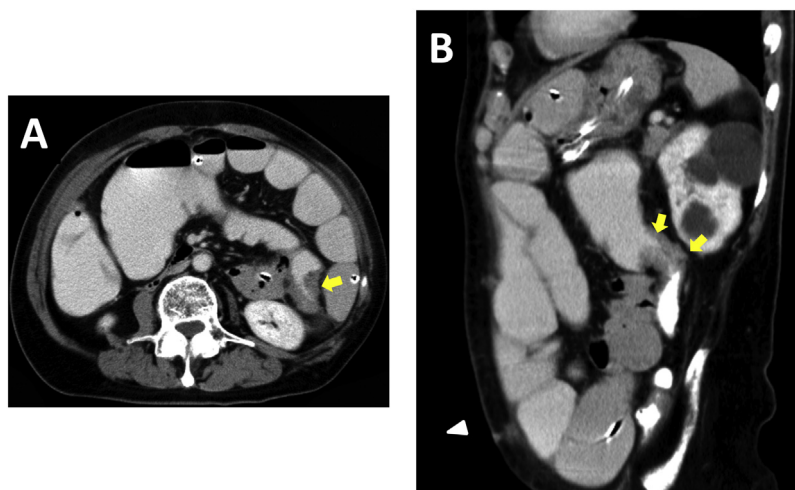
Contrast-enhanced computed tomographic scans of the abdomen obtained on the fourth day after re-admission, showing that the intestinal wall at the anastomosis (yellow arrow) and the surrounding region were unchanged, as compared with the status at the time of re-admission. However, dilatation of the colon proximal to the anastomosis had markedly worsened.
